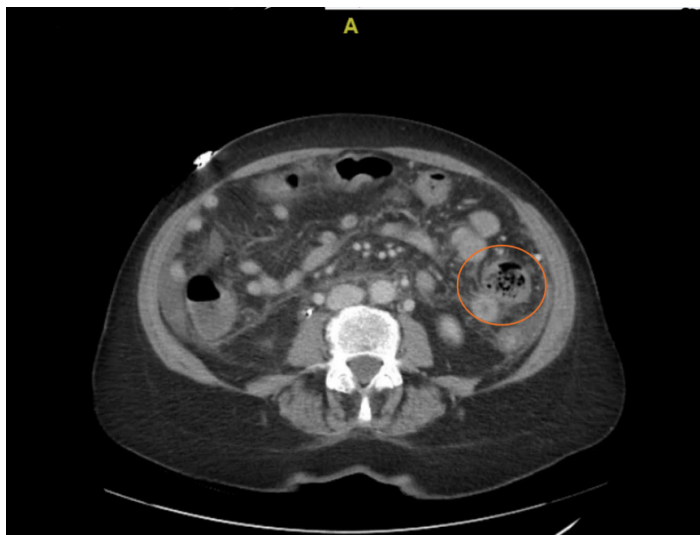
A single view of a Multi-detector CT imaging of the abdomen and pelvis performed using the standard protocol bolus administration of intravenous contrast which showed mild thickening of the mild colonic thickening in the ascending and transverse segments (red circle).
